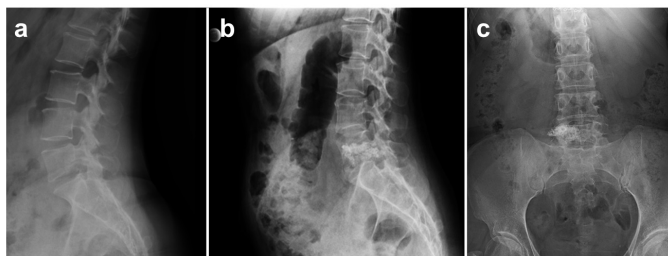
A 46-year-old female patient with metastatic breast cancer to the L5 vertebra. Preoperative (a) and 12-month follow-up radiographs (b, c). Patient's pain decreased from 9/10 to 4/10 after treatment and at the last follow-up
